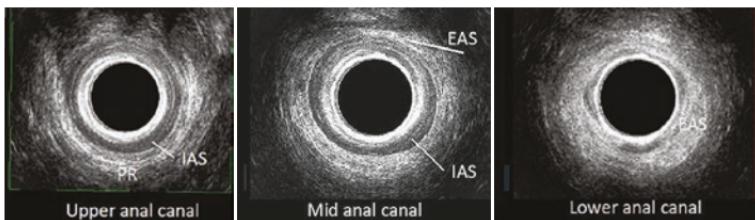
Three-dimensional ultrasound of internal and external anal sphincters, and puborectalis muscle, courtesy of Dr. V Patton, from the St George Hospital Pelvic Floor Unit, Anorectal Physiology Laboratory
